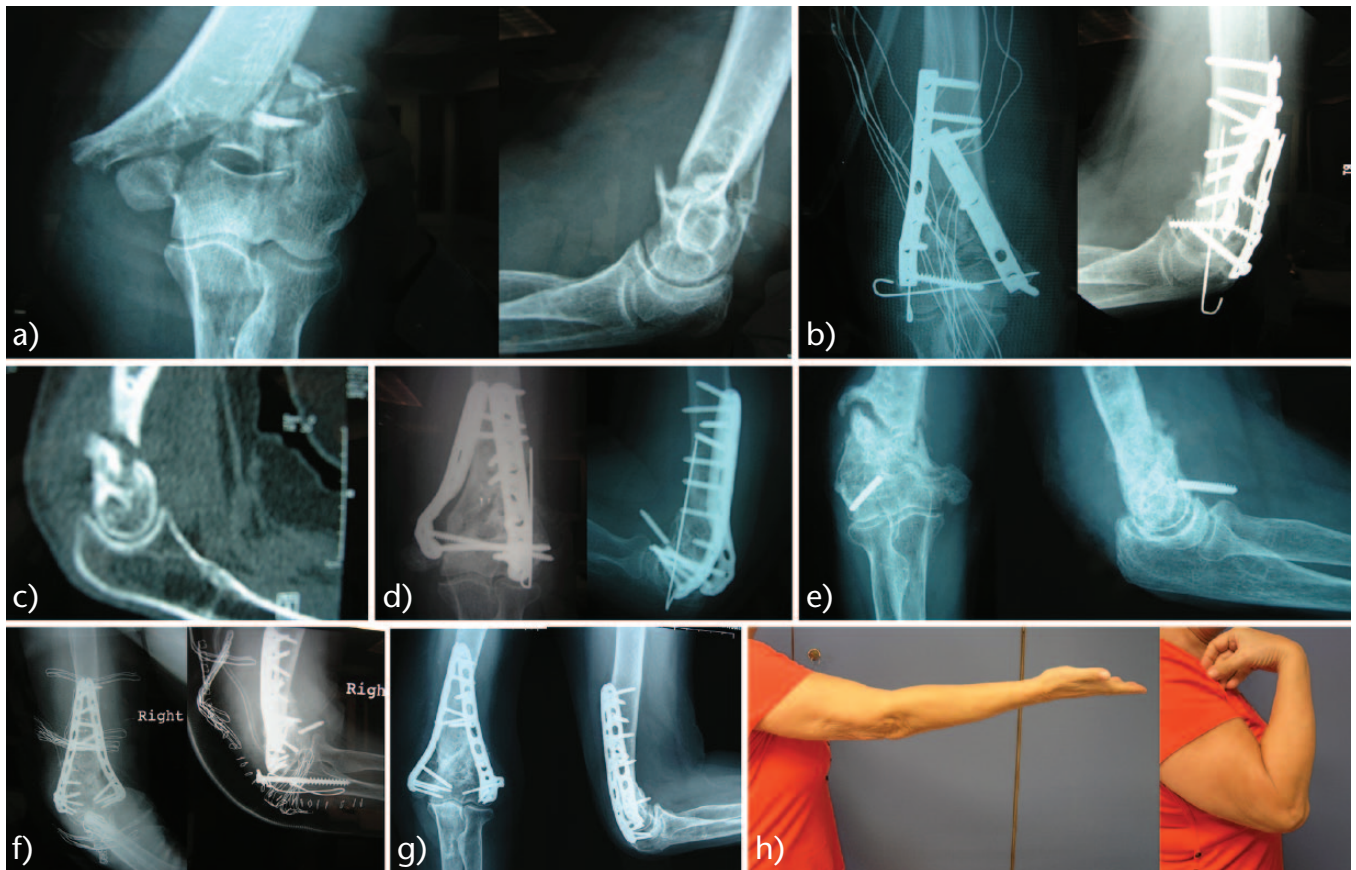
Fracture of the distal humerus in 52-year-old female treated with ORIF (double plating) with no proper surgical technique. A: anteroposterior radiograph of the distal humerus showing supra and inter-condylar fracture with comminution and B: lateral radiograph of the distal humerus showing supra and inter-condylar fracture with comminution. C: intraoperative image of the distal humerus fracture showing a gap in the metaphyseal area. D: anteroposterior radiograph of the elbow and E: lateral radiograph of the elbow seven months postoperative showing nonunion in the supracondylar area. The ulnar-medial plate is too short. The olecranon osteotomy is stabilized with tension-band technique; however, it is insufficiently fixed and not compressed.
